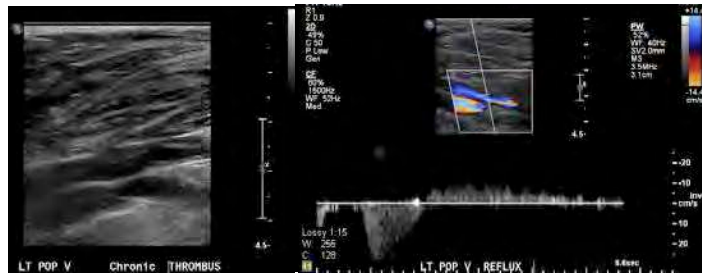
Axial deep vein reflux from the common femoral to the calf veins in a male patient who presented with skin damage after recurrent episodes of deep vein thrombosis in the left lower extremity. Skin damage is seen more often in patients with recurrent episodes of thrombosis and in those with both reflux and obstruction as in the current patient. The image on the left panel shows the chronic intraluminal changes in the popliteal vein with prominent wall thickening and intraluminal fibrous tissue. The image on the right demonstrates significant reflux on the Doppler waveform.
